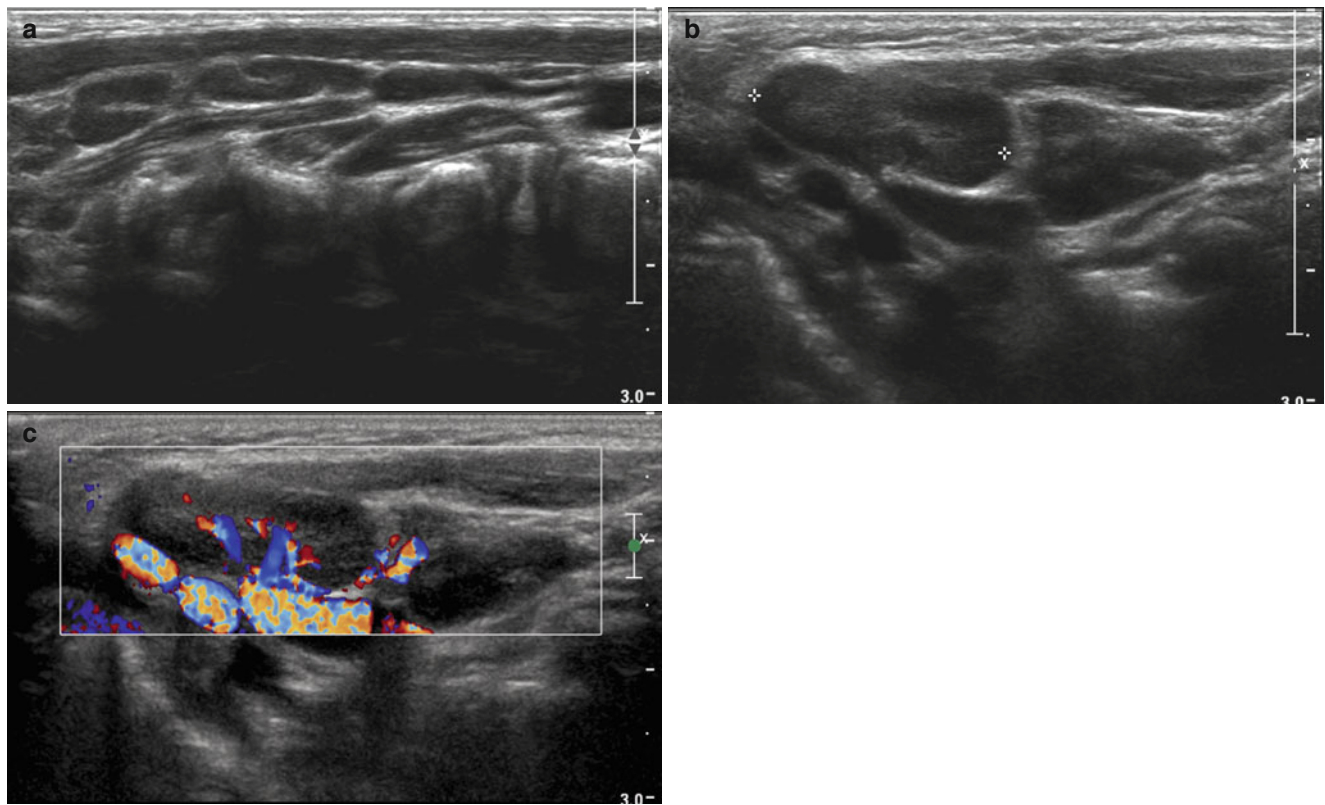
Reactive lymph node hyperplasia in a 3-year-old boy who presented with mild fever and palpable nodules. (a, b) Ultrasound images through the right upper neck show multiple ovoid or elongated hypoechoic lesions with central linear echogenicity representing central
